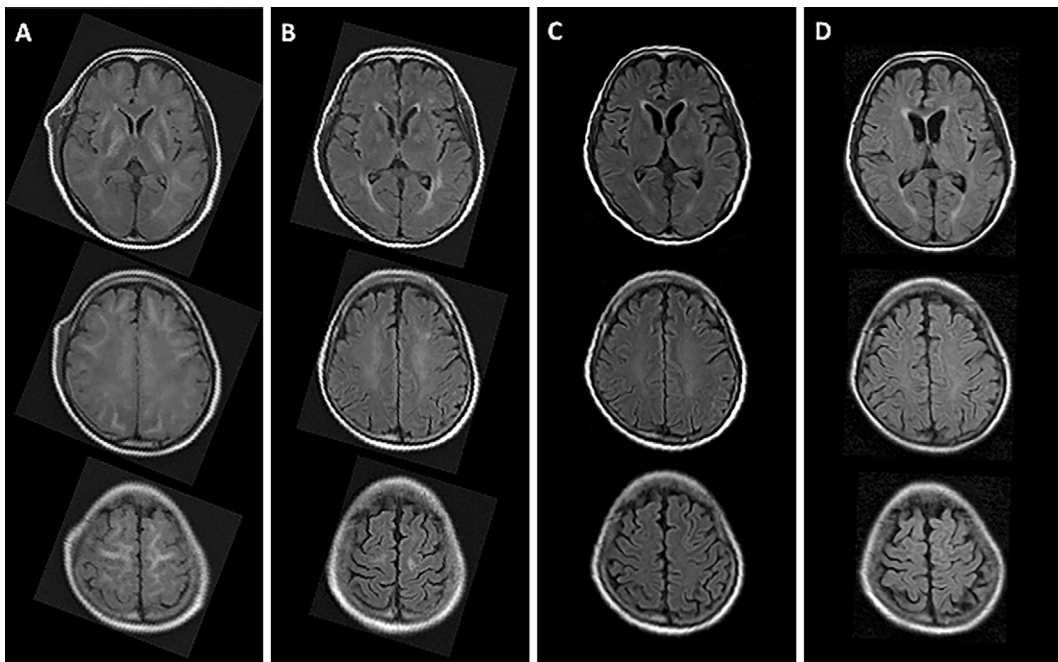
Time course of MRI. Fluid-attenuation inversion recovery (FLAIR) images showed diffusely increased signal intensity in cerebral white matter on hospital day 7 (A) and this changes was improving gradually, on day 20 (B), day 36 (C) and day 48 (D).
